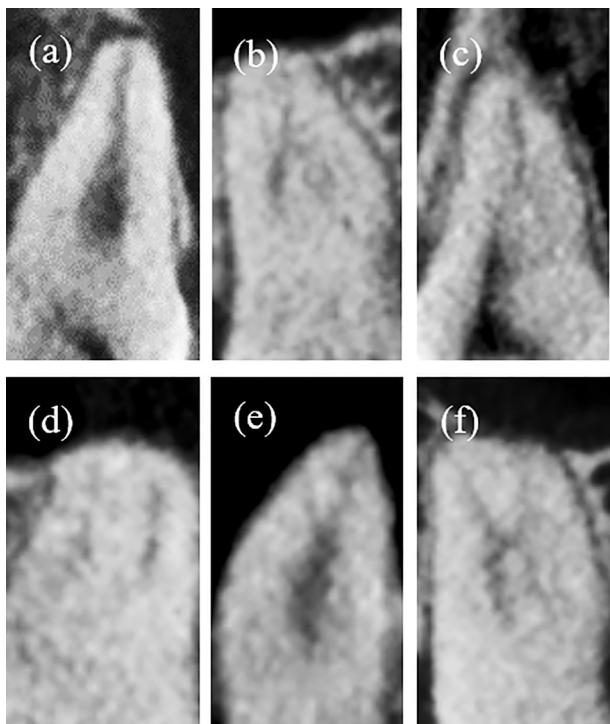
Representative CBCT scans showing mesiobuccal roots of the maxillary first molar classified with the Vertucci classification.² (a) Type I (1), (b) Type II (2-1), (c) Type III (1-2-1), (d) Type IV (2), (e) Type V (1-2) and (f) Type VI (2-1-2). Types VII (1-2-1-2) and VIII (3) were not identified in this study.
